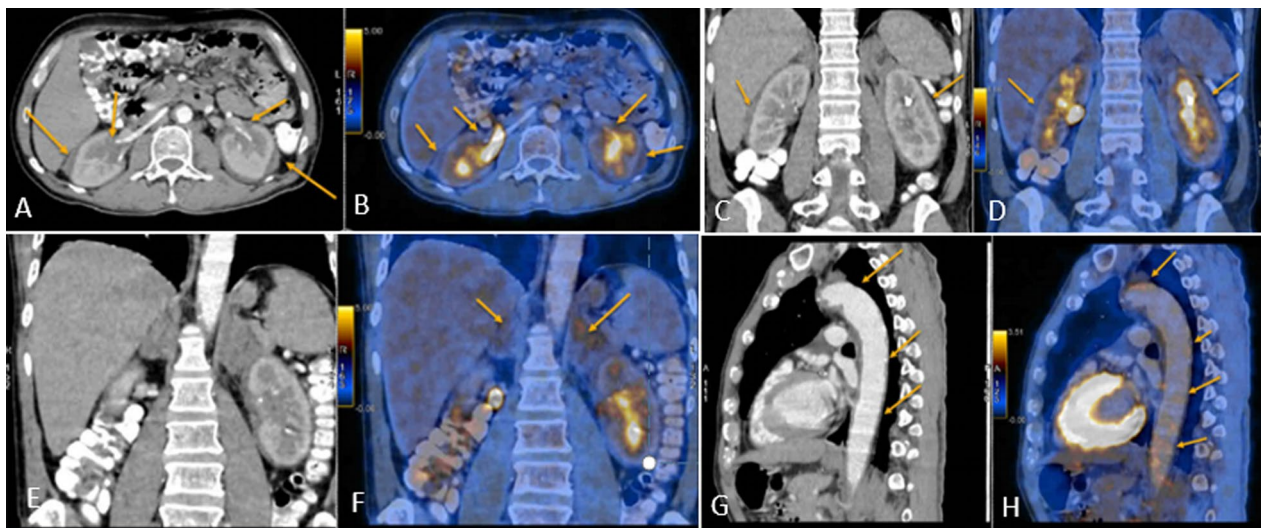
Positron emission tomography scan of a 60-year-old male patient diagnosed with Erdheim–Chester disease reveals a perinephric rim of soft tissue thickening extending in bilateral renal sinuses bilaterally (A, C), and corresponding uptake images reveal minimal FDG activity (SUV max. 3.3) in this region (B, D). Both adrenal glands appear bulky (E) and show mild diffuse increased FDG activity (SUV max. 3.8) (F). Soft tissue thickening is seen along aorta (G) which demonstrates mildly FDG avid (SUV max. 3.4) wall uptake (H)
